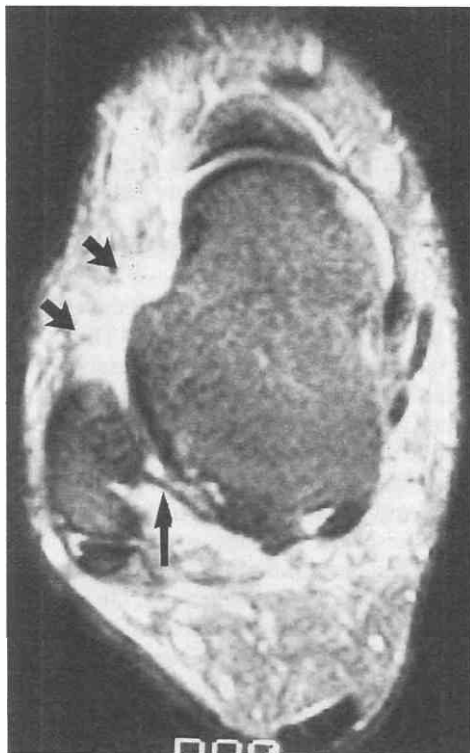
On an axial T2-weighted image, the posterior aspect of articular fluid is well marginated by the posterior talofibular ligament (*long arrow*). The fluid extends too far anteriorly with an irregular margin secondary to a tear of the anterior talofibular ligament (*short arrows*).
